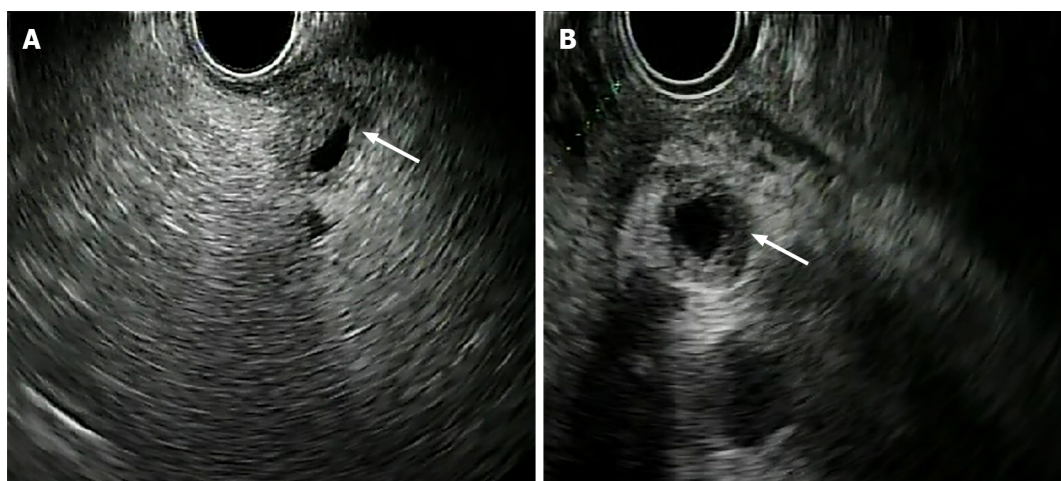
Two cases of cholangiocarcinoma evaluated with endoscopic ultrasound. A: Distal stenosis of the main biliary tract; B: Stenosis of the proximal-middle tract of the main biliary duct. Arrows indicate the stenotic tract.
